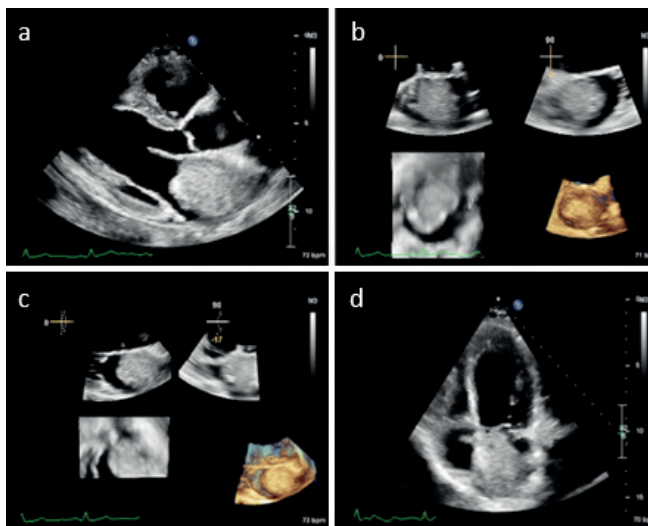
Transthoracic echocardiography images. A) Parasternal long axis view with a large echo density in the left atrium suggestive of a myxoma. B) Three-dimensional (3D) view of the myxoma in the parasternal short axis view combined with orthogonal view. C) Parasternal long axis view 3D view of the myxoma in the left atrium combined with orthogonal view. D) Apical 4 chamber view of the myxoma in the left atrium.
